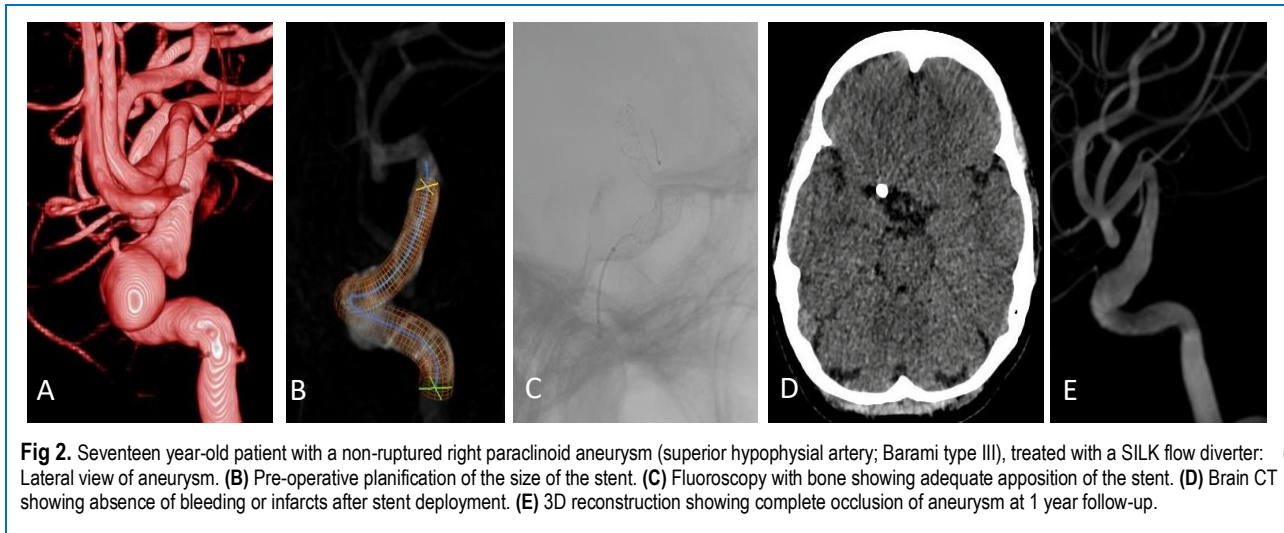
Seventeen year-old patient with a non-ruptured right paraclinoid aneurysm (superior hypophyseal artery; Barami type III), treated with a SILK flow diverter: (A) Lateral view of aneurysm. (B) Pre-operative planification of the size of the stent. (C) Fluoroscopy with bone showing adequate apposition of the stent. (D) Brain CT showing absence of bleeding or infarcts after stent deployment. (E) 3D reconstruction showing complete occlusion of aneurysm at 1 year follow-up.
